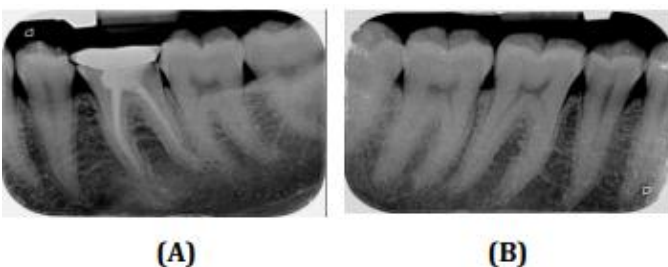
IOPA radiograph of the (A) test site and (B) control site
